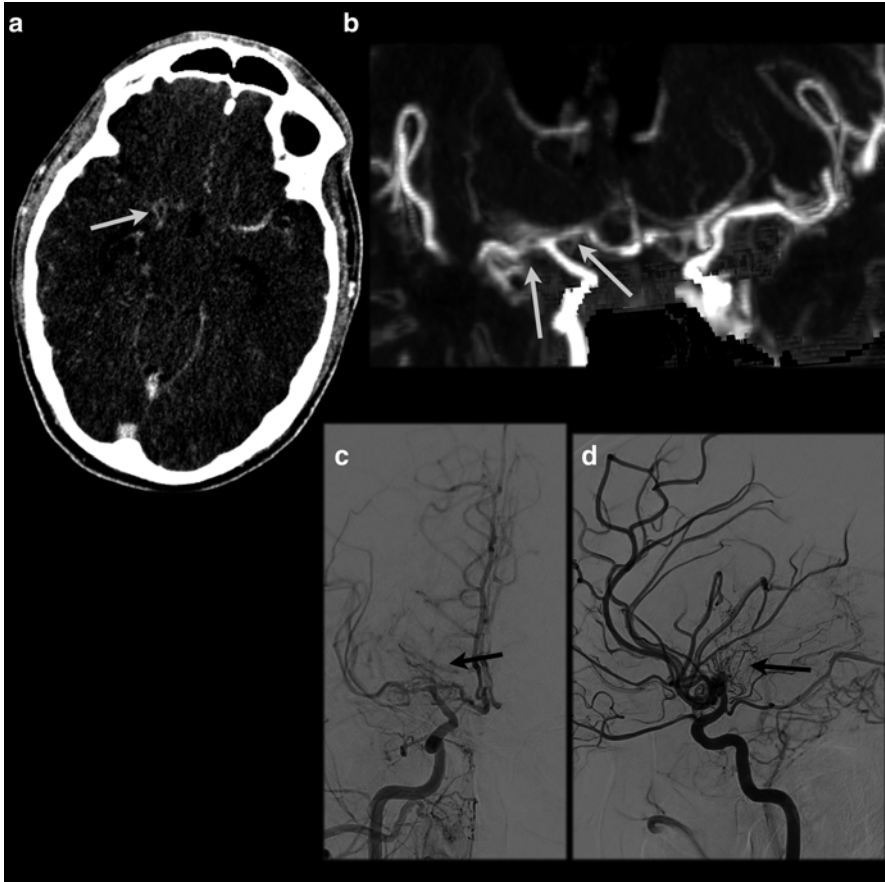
A 38 y/o male with a history of cocaine abuse presented with headache, MRI (not shown) demonstrated multiple old and recent cerebral infarcts bilaterally, mainly supratentorial. Steno-occlusive disease was suspected and subsequently a CTA was performed to depict the vascular status. Source images demonstrate the collaterals filling with contrast (a), MIP shows occlusion of the right M1 and A1 segments with only faint visibility of collateral vessels (b). DSA confirms the occlusions of the M1 and A1 segments including the lenticulostriate collaterals, resembling a “puff of smoke,” suggestive of Moyamoya syndrome (c, d)
